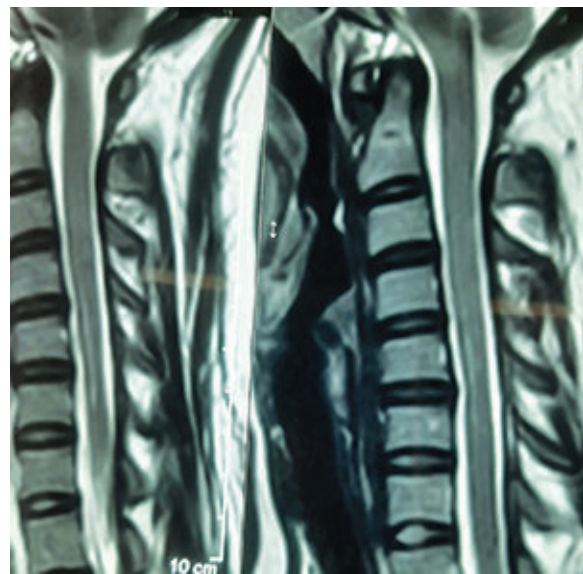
MRI of cervical spine in flexion view showing narrowing of the cord at C5, C6 level with intramedullary signal changes extending from C5 to C6 level and mild anterior displacement of posterior dura.
